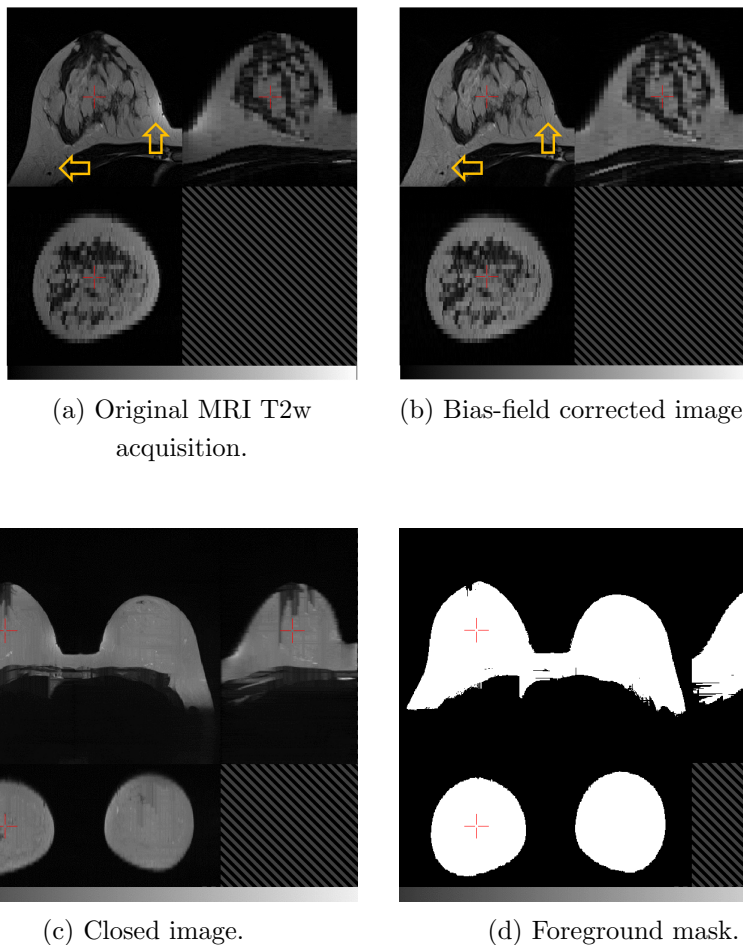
Orthogonal slices through (a) a T2 weighted MRI and (b) the corresponding image after bias-field correction, with arrows indicating regions that are particularly improved by the processing. The “closed” T2w image is shown in (c) and foreground mask  $I_{fg}$  in (d). In each image the top-left quadrant is the axial slice, the top-right is sagittal and the bottom-left is coronal.
